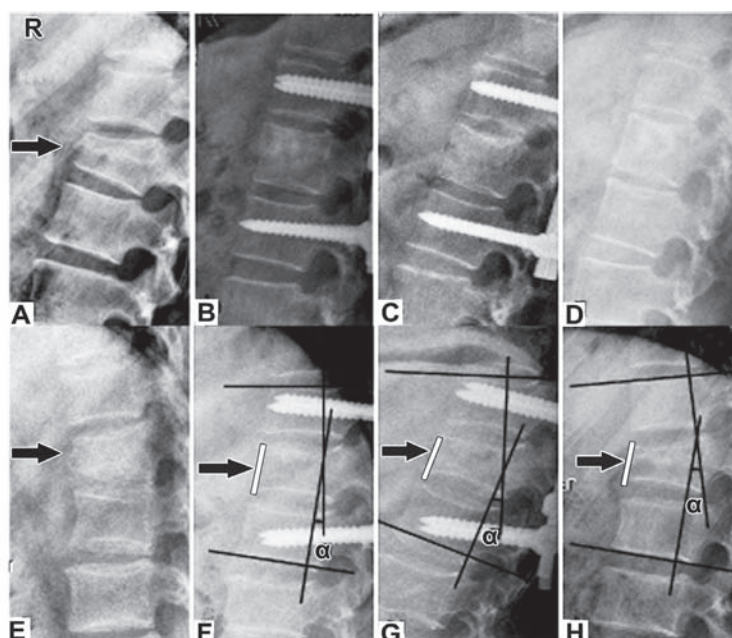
An image from a 35-year-old male showing: A) preoperative lateral radiograph indicated a burst fracture of L1 (arrow); B) immediate postoperative lateral radiograph demonstrated excellent height restoration; C) lateral radiograph 3 months after surgery; and D) lateral radiograph at final follow-up indicated no loss of correction. An image from a 36-year-old-female showing: E) preoperative lateral radiograph indicated a burst fracture of T11 (arrow); F) immediate postoperative lateral radiograph indicated an excellent restoration of height (white line) and correction of local kyphosis angle (LKA [α]), however, lateral radiograph 3 months after surgery (G) (arrow, white line), and lateral radiograph at final follow-up (H) demonstrated a collapse of fractured vertebra (arrow, white line) and a correction loss of LKA [α].
